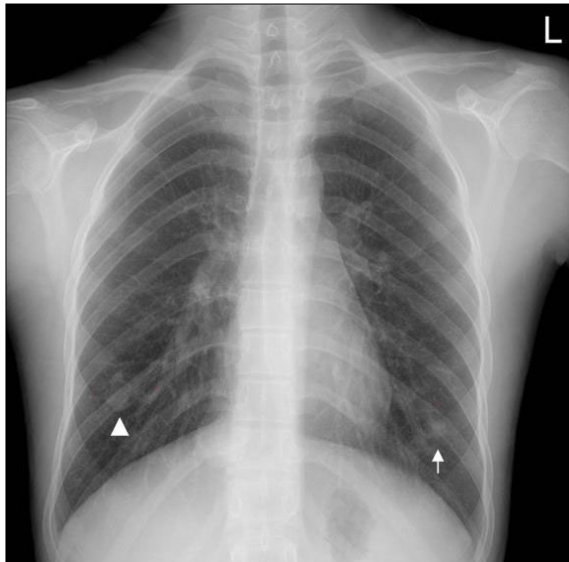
Chest X-ray shows 3 cm sized well demarcated lobular mass in right lower lung field (arrow head) and 1 cm sized nodule in left lower lung field (arrow).
